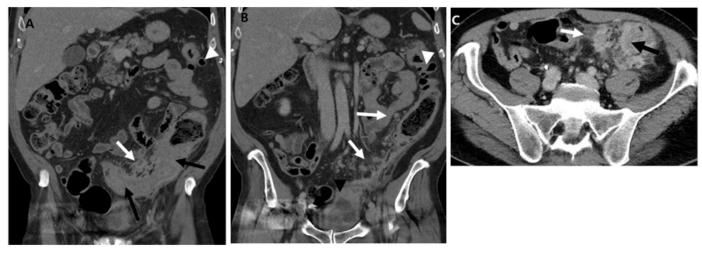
(A - C): Initial Computed tomography with intravenous contrast-enhancement
